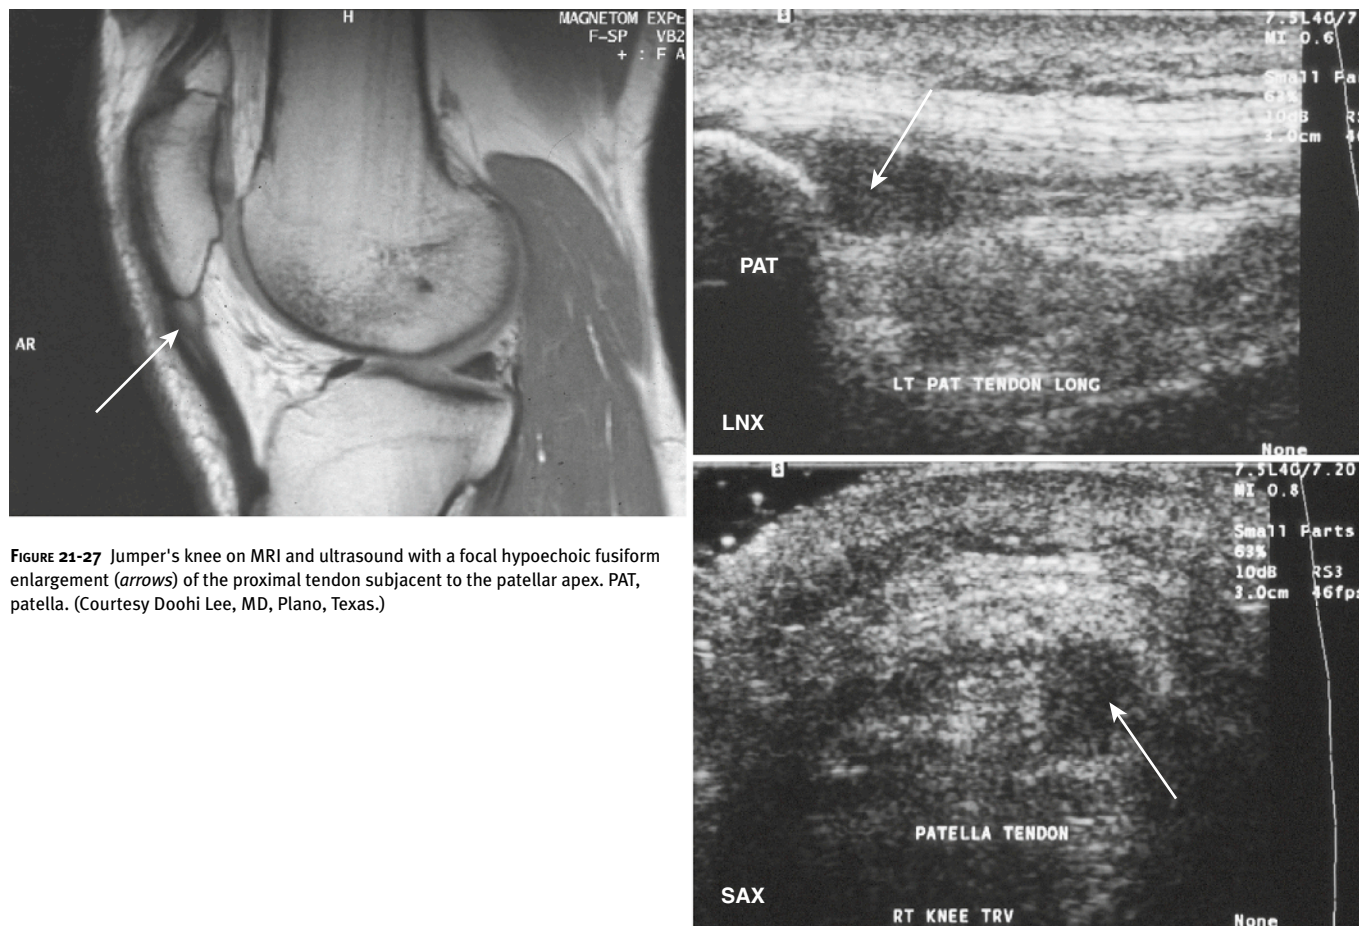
Jumper's knee on MRI and ultrasound with a focal hypoechoic fusiform enlargement (arrows) of the proximal tendon subjacent to the patellar apex. PAT, patella. (Courtesy Doohi Lee, MD, Plano, Texas.)
